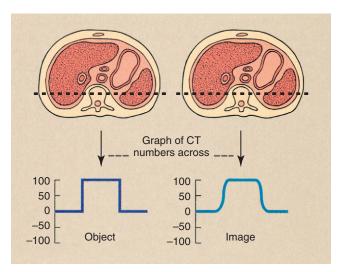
Computed tomography (CT) examination of an object organ with distinct borders results in an image with somewhat blurred borders. The actual CT number profile of the object is abrupt, but that of the image is smoothed.
